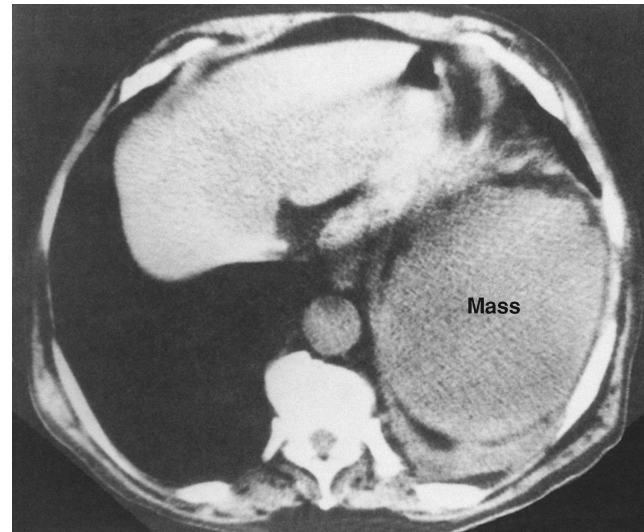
An abdominal computed tomographic scan, enhanced by contrast material, confirming the diagnosis of splenic abscess.
